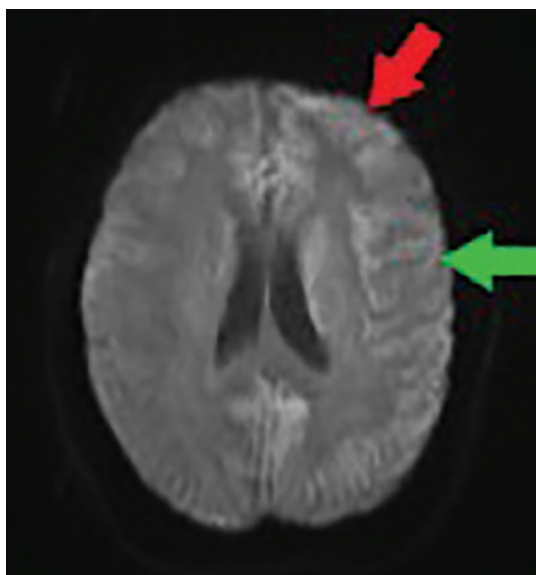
Diffusion-weighted magnetic resonance imaging at admission shows cortical bifrontal (red arrow) and parietal (green arrow) diffusion (cortical ribboning), with greater intensity on the left. No thalamic hyperintensity was seen. Note that the quality of this image was affected by patient movement during the procedure, in spite of attempts to sedate her.
